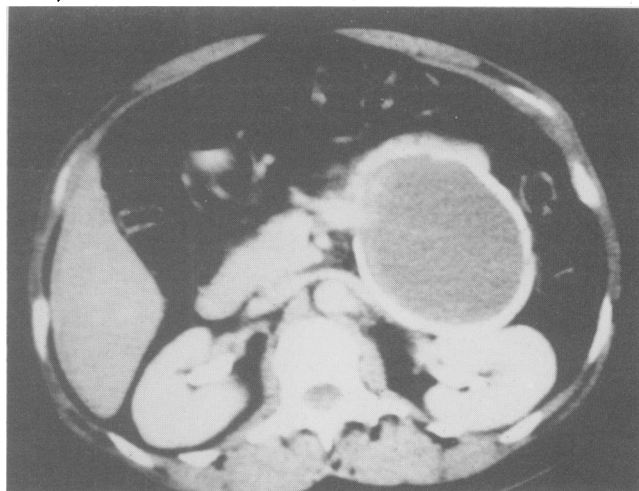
Contrast-enhanced CT scan (case 2) showing a large single cystic adenocarcinoma with calcified wall. There is no associated mass seen.
